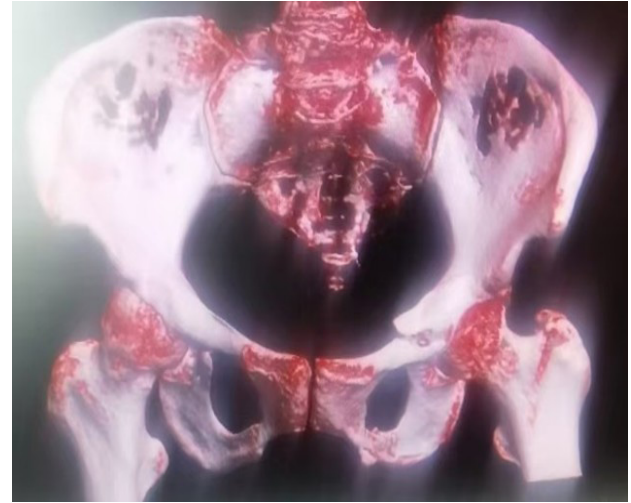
Three-Dimensional CT Reconstruction of the Pelvis
